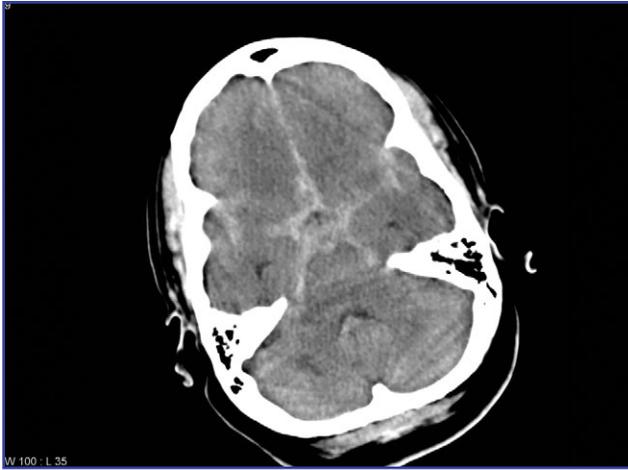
CT image of head showing subarachnoid hemorrhage.
